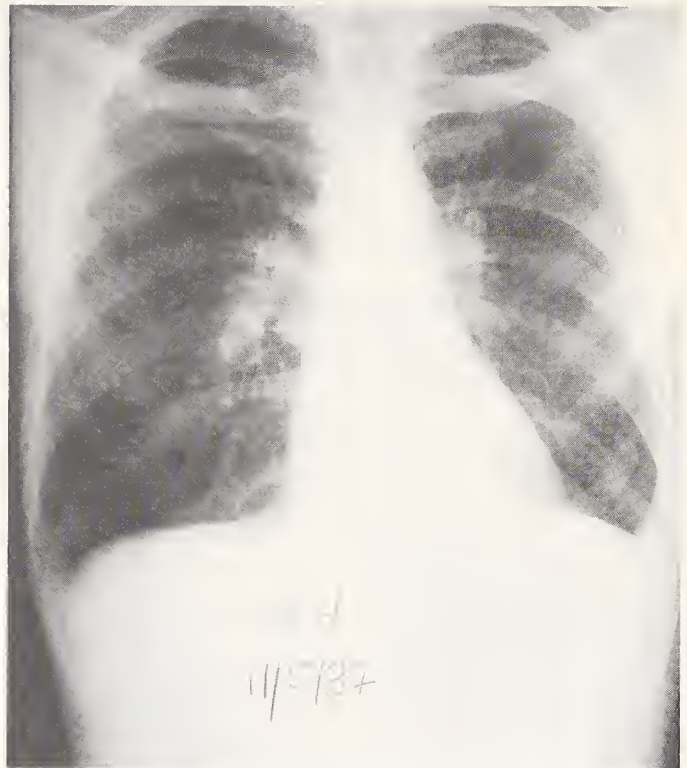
Chest roentgenogram after treatment with steroids.
